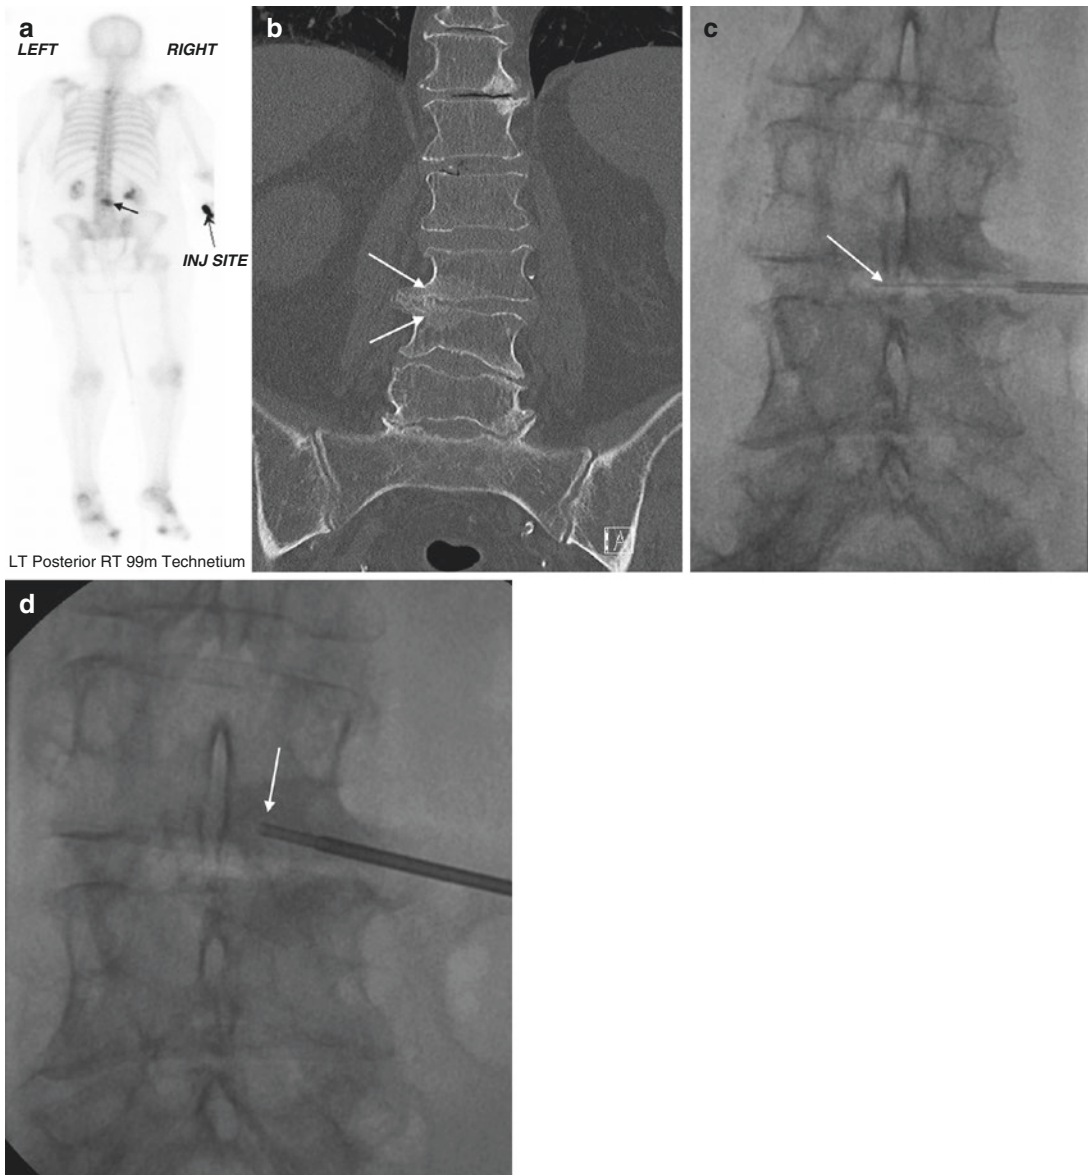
A 67-year-old female with history of breast cancer and low back pain. Focal radionuclide uptake (*arrow*) is seen within the lumbar spine on the static image from the bone scan (a). Coronal CT reformation in bone window algorithm (b) shows focal asymmetric sclerotic change adjacent to a prominent lateral osteophyte at L3–L4 (*arrows*); this finding is present at other spinal levels.
